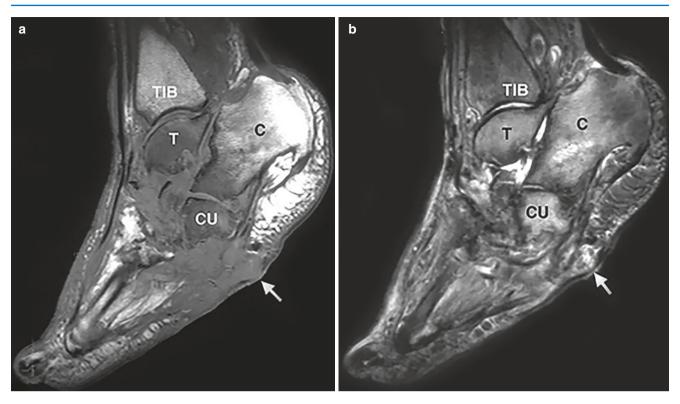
Rocker bottom deformity and ulceration at focus of high plantar pressure on MRI. (a) Sagittal T1-weighted and (b) STIR images show disruption of the talonavicular joint causing collapse of the longitudinal arch. These changes produce the classic "rocker bottom" deformed and the second secon
